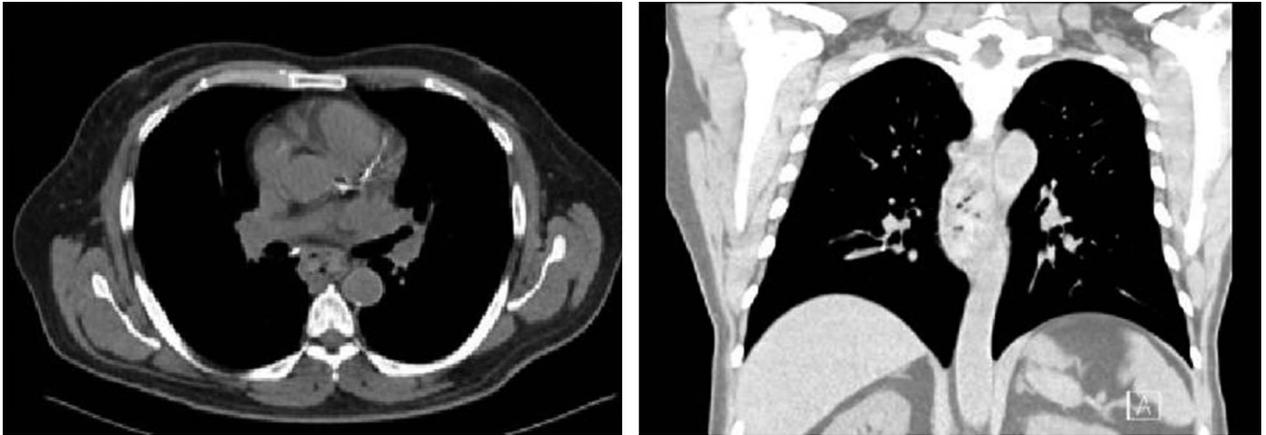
Computed tomography (CT) chest (2 views). CT of the chest shows an 8.6-cm segment distended and filled with food debris from below the carina to 4 cm above the gastroesophageal junction.
